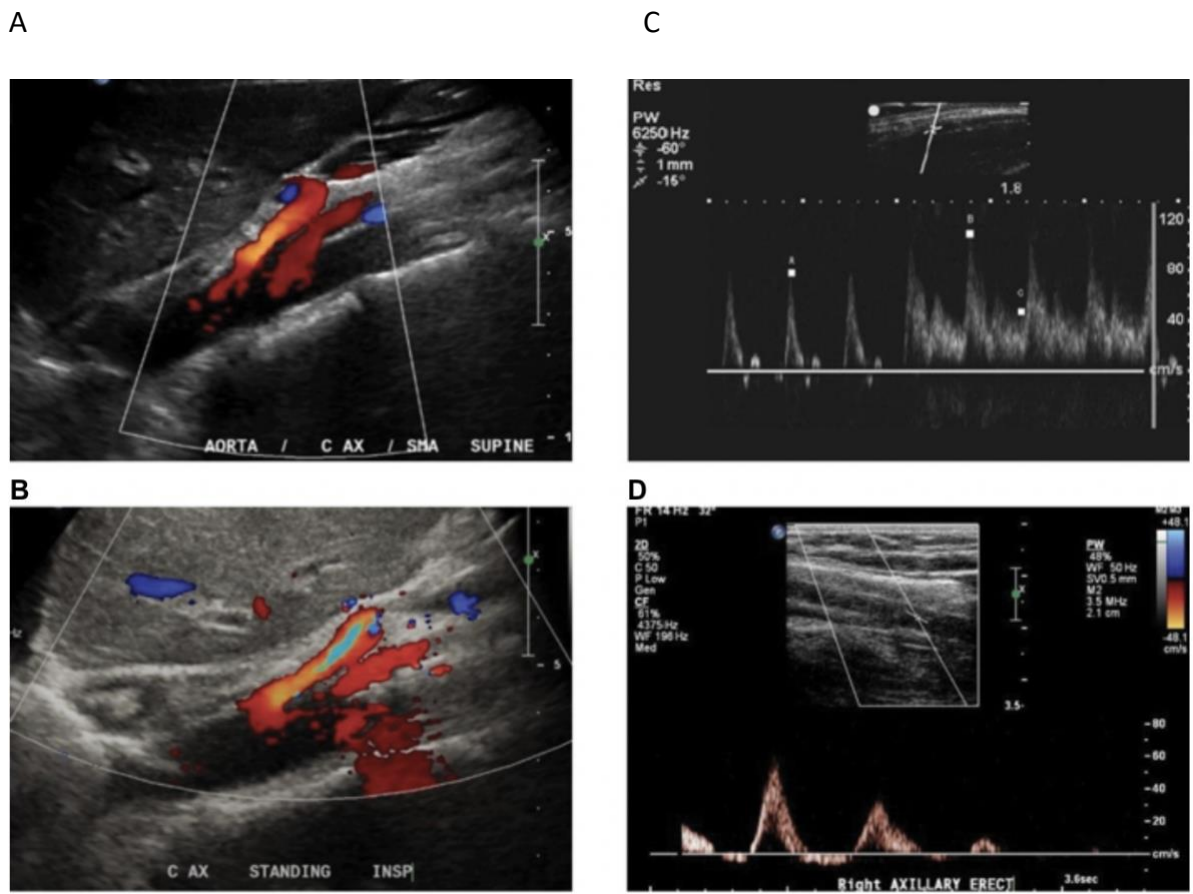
Pulse Wave Doppler ultrasound in vascular compression syndrome
